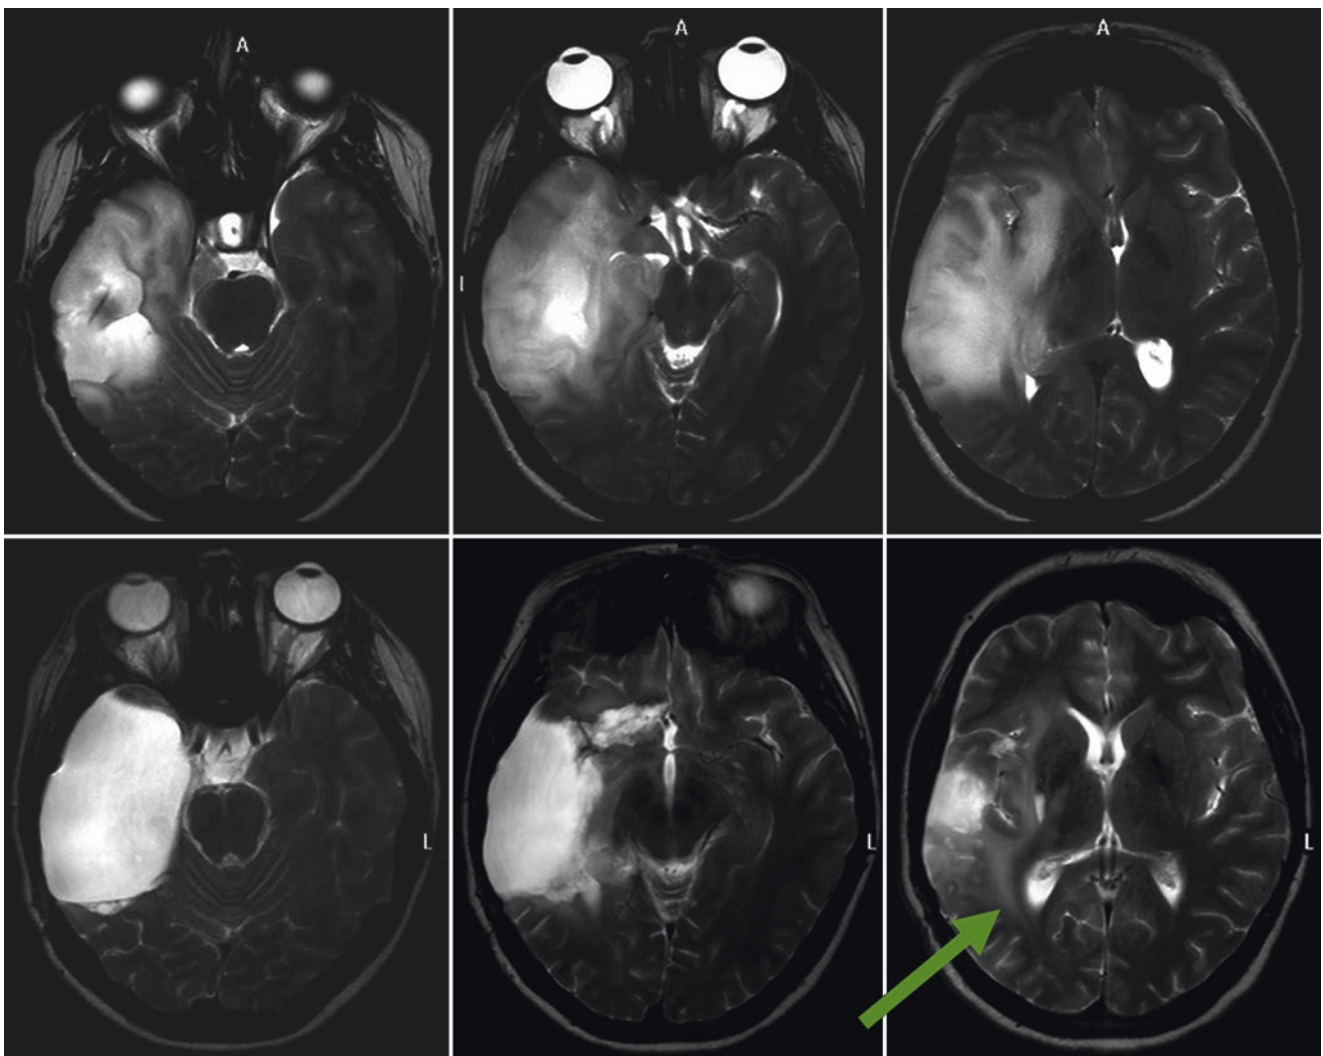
Large right temporal tumor and tailored resection. T2-weighted axial MRIs of a 17-year-old patient. The patient developed epilepsy with simple and complex partial seizures, which were easily controlled with anticonvulsive medication. An infiltrating astrocytoma was suspected, and the patient underwent uneventful subtotal tumor resection. At that time, she had just started to obtain a driving license, and a plan (shared decision making) was made. Her goal was to
